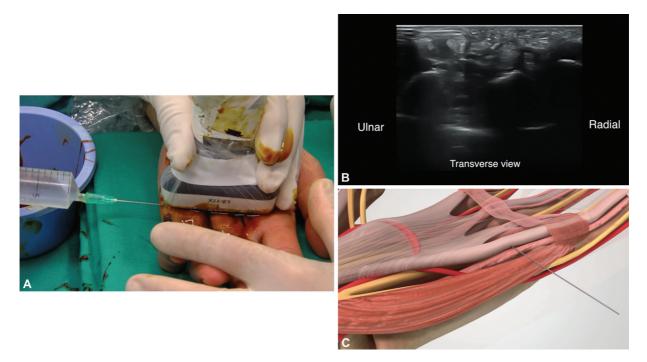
(A, B, C, D) Ultrasound-guided aponeurotomy in Dupuytren disease. The portals are chosen on the ulnar side of the ray with the probe over the cord.
